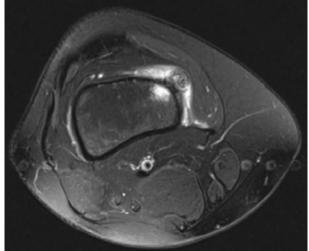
MRI findings. An axial T1-weighted MRI image that shows a low signal intensity at the margins of the lesion. An axial T2-weighted MRI image that shows a high signal intensity at the margins of the lesion.
